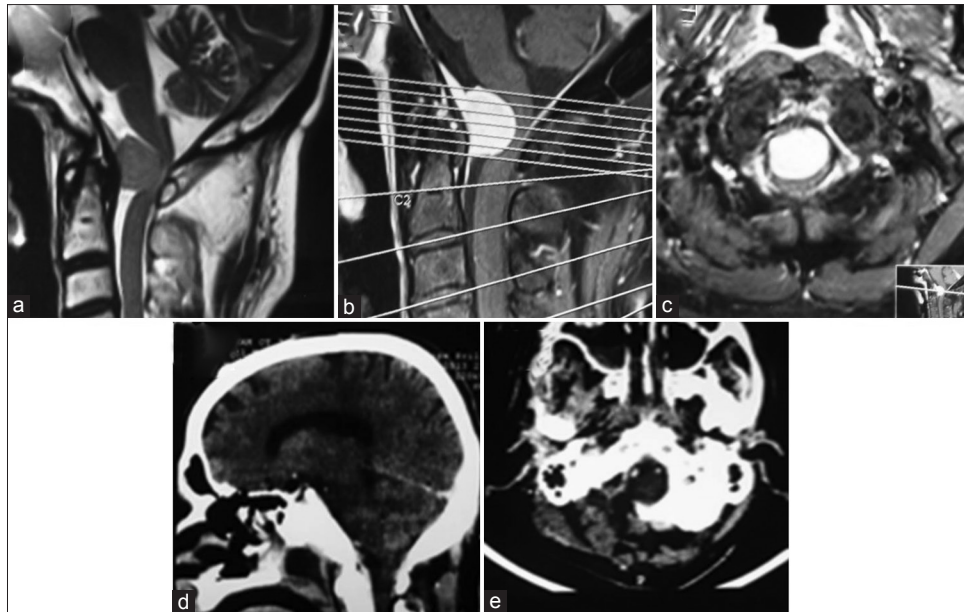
(a) T2 sagittal image shows a ventrally located iso- to slightly hyperintense mass at the foramen magnum without any cord intensity changes. On contrast administration, it shows homogenous and uniform enhancement on contrast administration with a dural tail sign; (b) Axial contrast MRI shows a ventrolateral location of the mass with displacement of the cord posterolaterally toward the left; (c) Figure 1d and e show postoperative CT images with complete excision of the mass and bony exposure done during surgery
